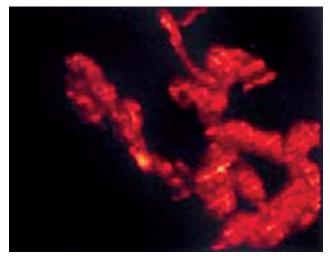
Non-enhanced three-dimensional power Doppler image of the same tumor. Less than three generations of penetrating intratumoral vessels are displayed within the solid part of the lesion
